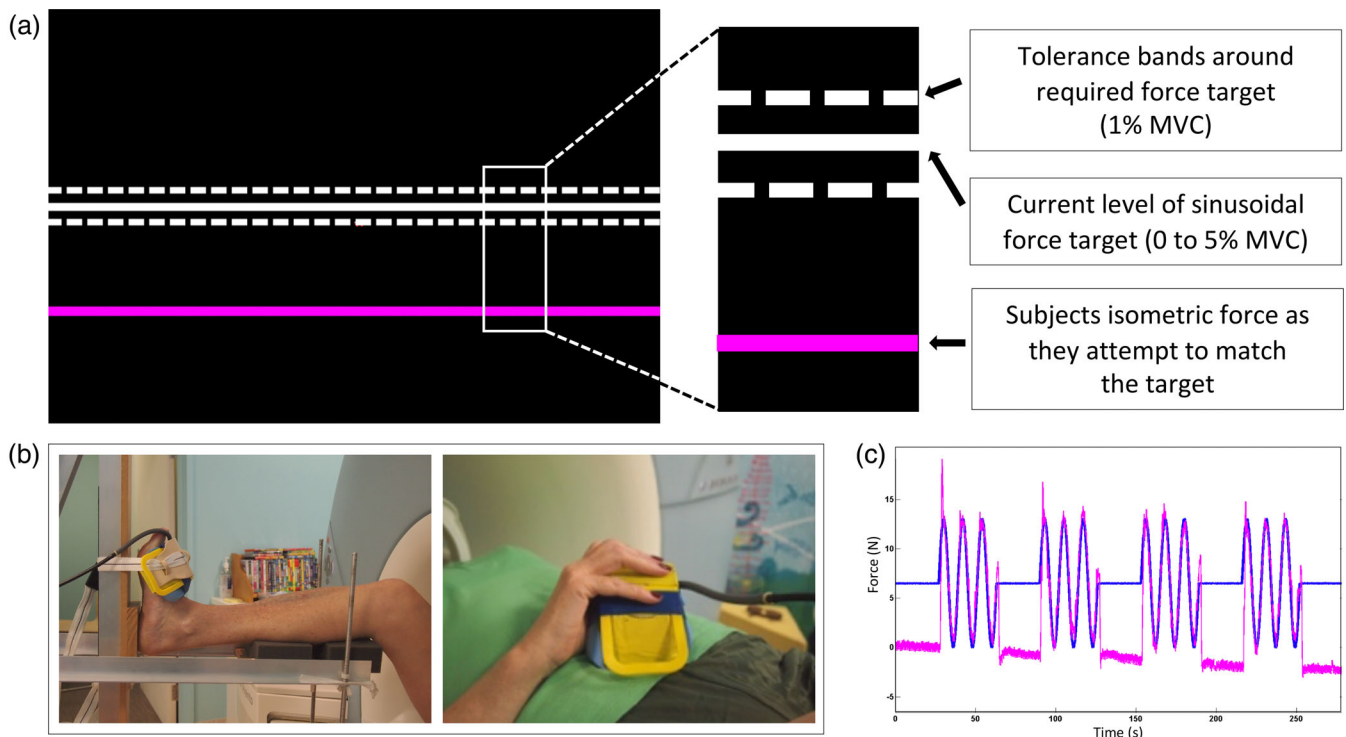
Force-matching task during functional MRI acquisition. (a) The task presented to the participants. The white line slowly moved up and down during a task block and the participants were asked to follow the white line as accurately as possible with the pink by squeezing and releasing their fingers or pulling their foot up and down to make the pink line hit the white line. (b) The MR compatible rig used to stabilise the foot and lower leg during the ankle motor task, that is, ankle dorsiflexion to match a force indicator displayed to the participant, is shown on the left. The sphygmomanometer cuff was either positioned over the dorsum of foot close as possible to metatarsal heads without covering toes or held in the right hand between the thumb and fingers (shown on the right image). (c) The blue line reflects the force in four contraction blocks interleaved with five periods of rest. The pink line is an example of the force produced by the participant to match the force indicator displayed on the black screen (white line)
